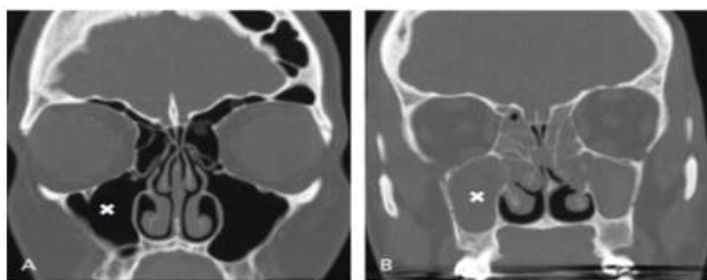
Computed Tomography of Nose And PNS
